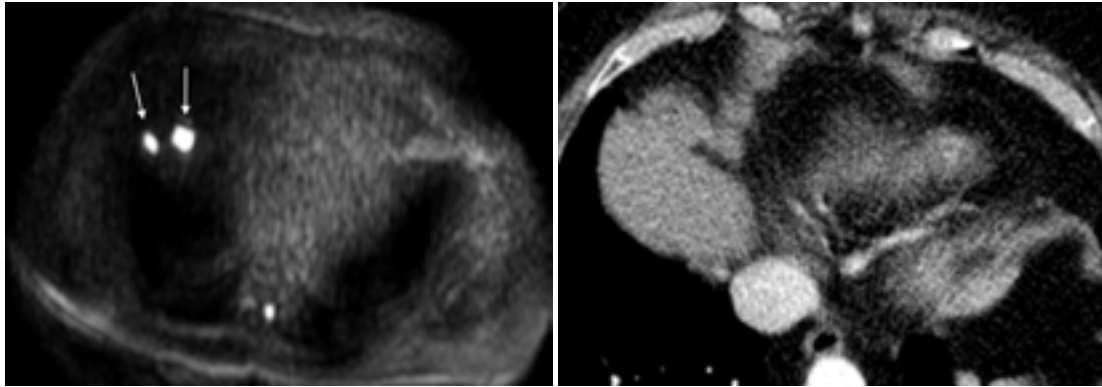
A 69-year-old woman with recurrent non-operable ovarian cancer (Stage IV). Progressive disease was suspected due to a rise of the tumor marker CA 125. Diaphragmatic metastases were depicted in DW MRI (5608/52, $b = 800 \text{ sec/mm}^2$) (a), but missed in CECT (b).
